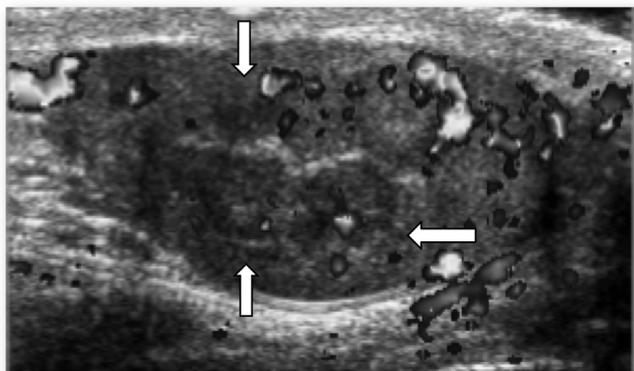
Doppler ultrasound of right testis reveals positive TART findings in 12-year-old male with salt-wasting form of classic CAH, advanced bone age and elevated 17-hydroxyprogesterone levels. TART was 12 × 12 mm in diameter (white arrows) and localized to testicular hilum (hyperechoic midline strip).
